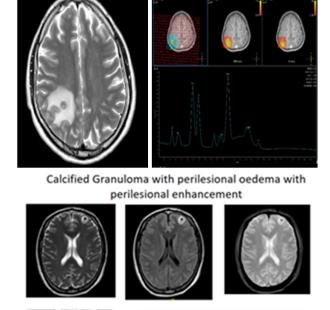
Different stages of Tuberculoma with various stages and sequences in MRI along with MRS
